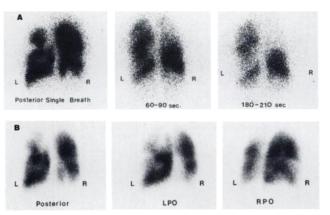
A 23-yr-old female nonsmoker on birth control pills, was referred for ventilation and perfusion scans because of sudden onset of shortness of breath. The chest x-ray showed no infiltrates. The washout images (A) reveal significant retention involving more than 50% of the lung fields. The washin ¹³³Xe image (A) shows defects matching the perfusion abnormalities seen on the posterior view (B). Pulmonary angiogram was negative for pulmonary emboli.
